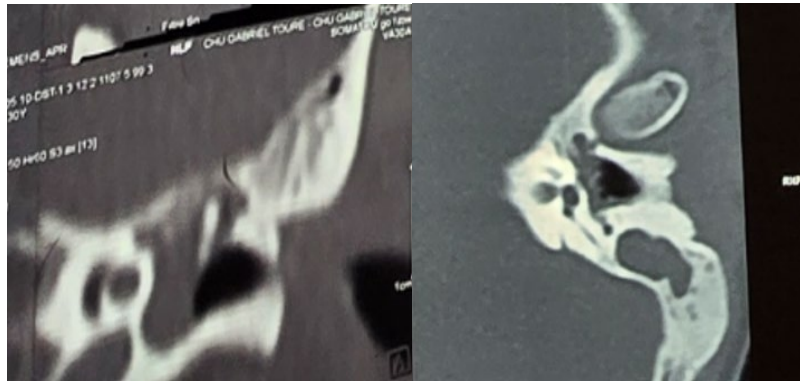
CT scan of the middle ear: tissue hypodensity filling the epitympanic and mesotympanic cavities.
